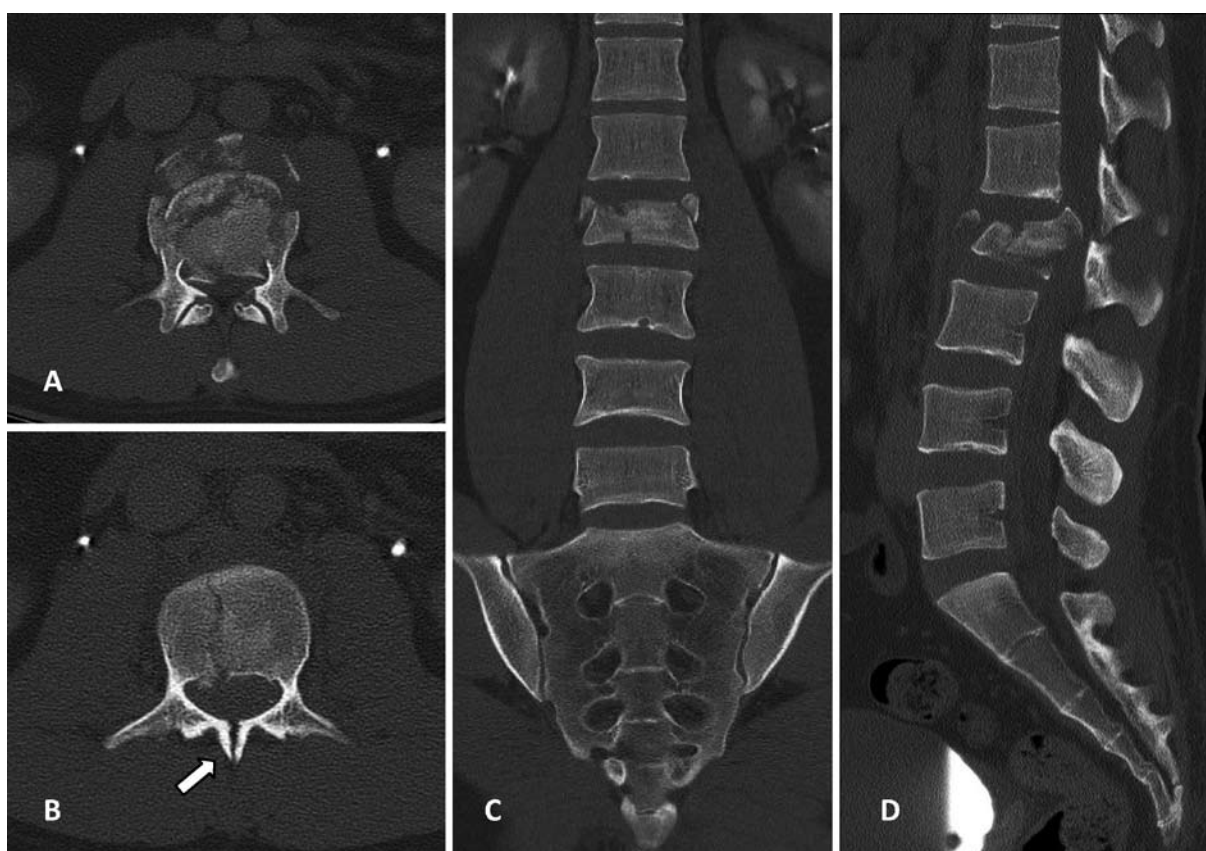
(A and B) Axial CT images showing the burst fracture with extension of the fracture into the base of the spinous process (arrow). Coronal (C) and sagittal (D) CT images demonstrating spinal instability with retropulsion of a fracture fragment into the spinal canal.
